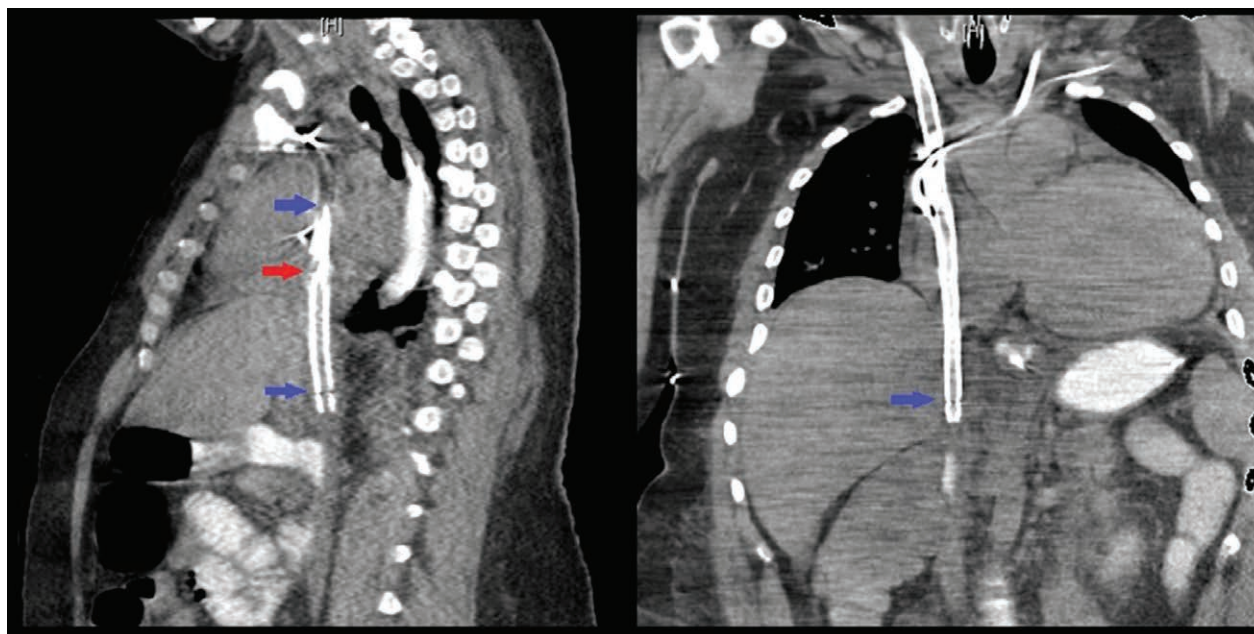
Computed tomography (CT) imaging of right internal jugular cannulation with a dual lumen Avalon Elite cannula. *Red arrows* represent return sites of oxygenated blood to the patient. *Blue arrows* represent drainage of venous blood from the patient. The outflow of oxygenated blood is directed across the tricuspid valve from a lumen in the right atrium. Venous drainage occurs through multiple cannula lumens in the superior vena cava and inferior vena cava. The tip of the cannula is in the intrahepatic IVC. A pulmonary artery catheter is also present. (Left) Sagittal chest CT view. (Right) Coronal chest CT view.
